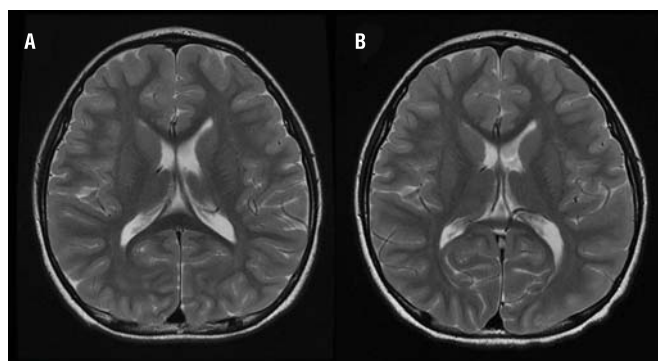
Magnetic resonance images of the patient's brain. (A) 1 week before the umbilical cord blood transplantation: no focal abnormality in the brain parenchyma, (B) 6 months after the umbilical cord blood transplantation: no significant changes were observed.
